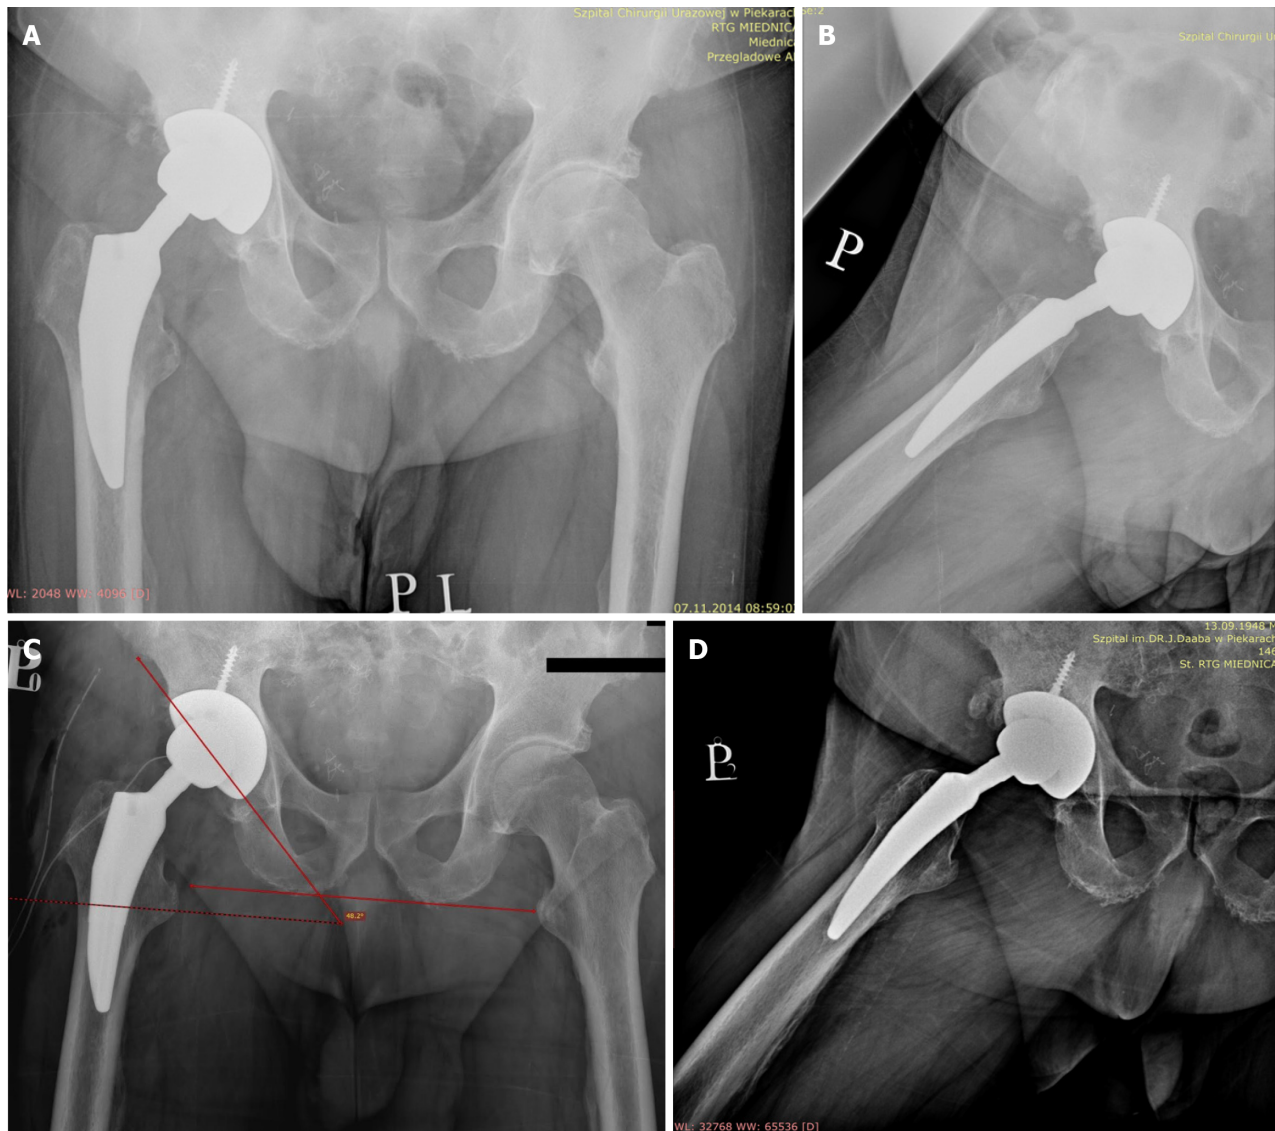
X-ray images of the right hip joint after total hip arthroplasty revision. A: After total hip arthroplasty revision; B: In lateral view after total hip arthroplasty revision; C: At 9 years after total hip arthroplasty revision showing acetabular cup at an inclination angle of 48.2°; D: In lateral view at 9 years after total hip arthroplasty revision.
